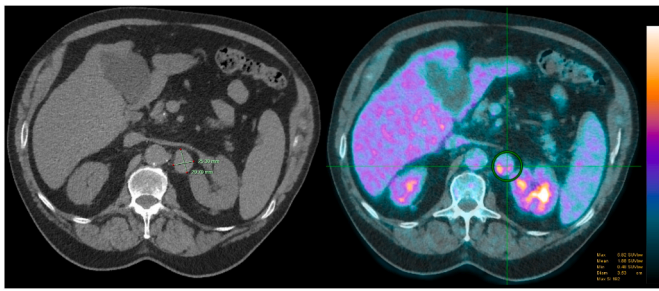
Computed tomography (CT) abdomen and pelvis demonstrating a 25 × 19mm left para-aortic lymph node (A). FDG Positron Emission Tomography (PET) highlighting a 5.8 SUV max para-aortic lymph node.
